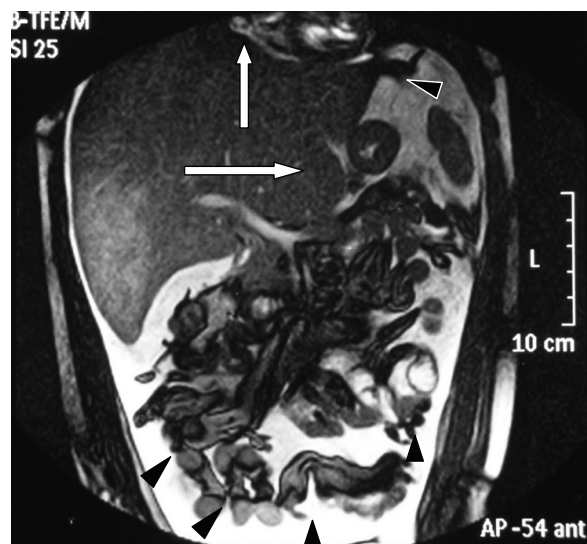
Magnetic Resonance Images acquired with T2-weighted sequences: hepatomegaly, caudate lobe enlargement (horizontal white arrow), lack of visualization of hepatic veins outflow (vertical white arrow), absence of thrombus within portal, splenic and mesenteric veins, splenomegaly and severe ascites (black arrowheads).
